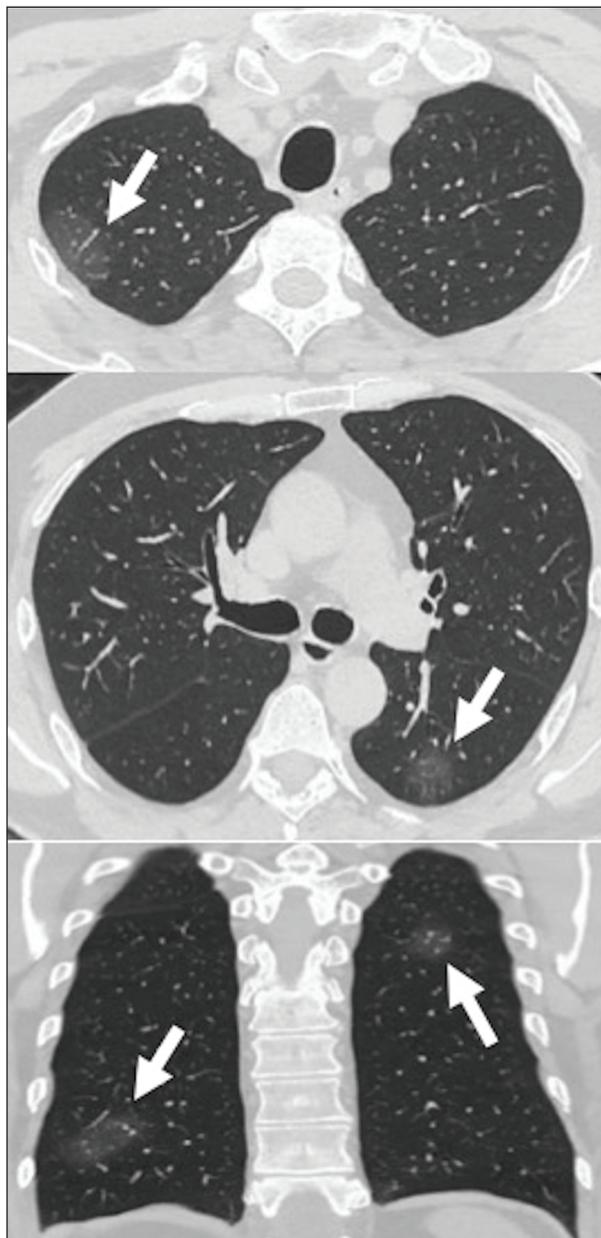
54-year-old man patient with fever and diffuse thoracic pain (RT-PCR test positive): the multiplanar chest CT images show multifocal and bilateral peripheral areas of patchy pure ground-glass opacities (white arrows).
